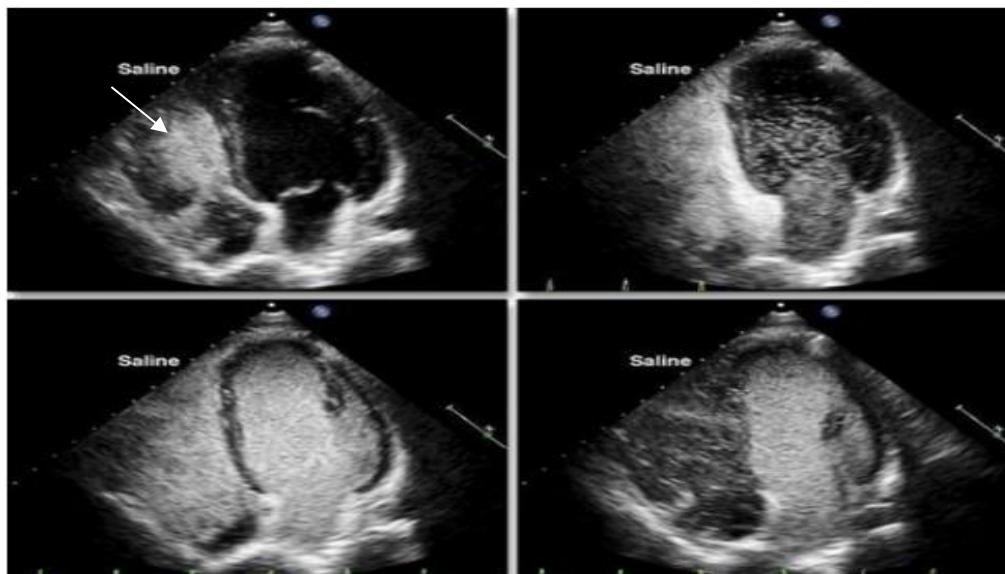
2-D transthoracic contrast enhanced echocardiography showing microbubbles in the left heart chambers (arrow) after three cardiac cycles after its appearance in the right ventricle in any of three injections.¹⁸
